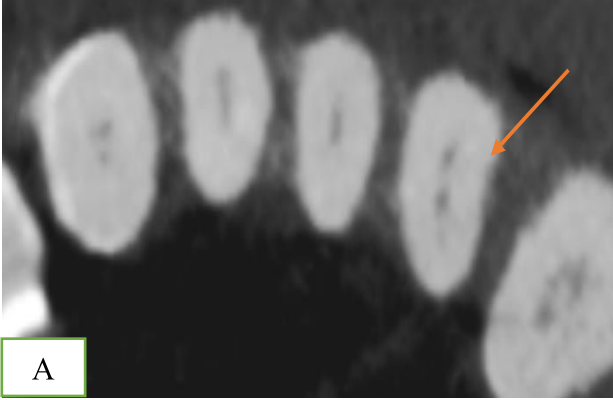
Cone-beam computed tomography images of a mandibular lateral incisor showing Type II Vertucci classification canal morphology (2-1) in the axial plane:(a) 2 canals at the coronal third, (b) 2 canals at the middle root third, (c) single canal at the apical third (D) coronal plane
